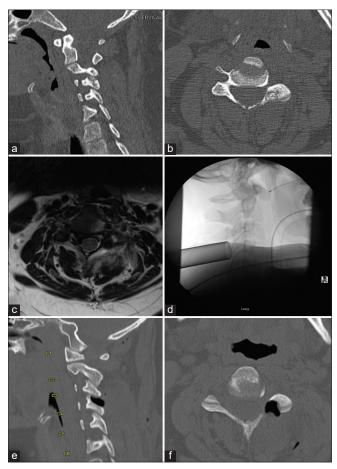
AP and lateral CT images of a subcentimeter mass located in the lateral mass of the left C4 (a and b). Axial T2 MRI imaging demonstrated a T2 hyperintense lesion in the left lateral mass at C4 (c). Lateral fluoroscopy showing the tubular retractor centered on the C3/4 facet joint (d). Lateral and axial CT images demonstrated a gross total resection of the C4 mass with minimal bony resection (e and f).
